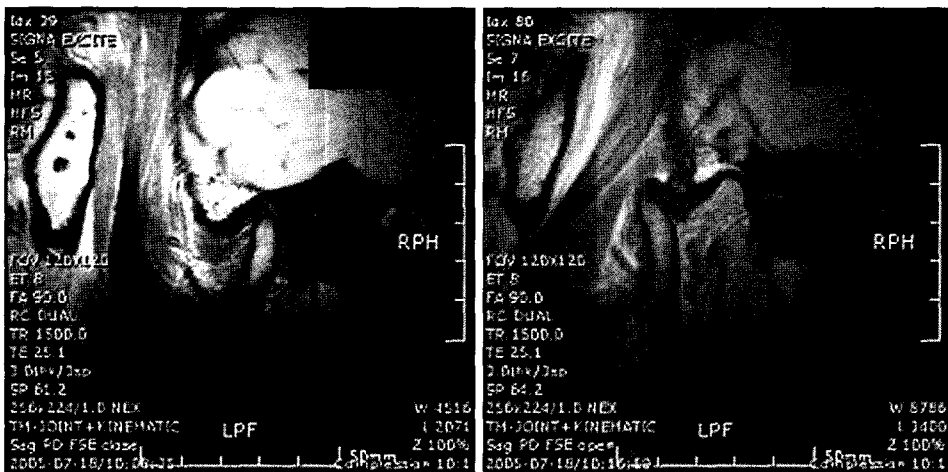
The static MRI of normal TMJ.
